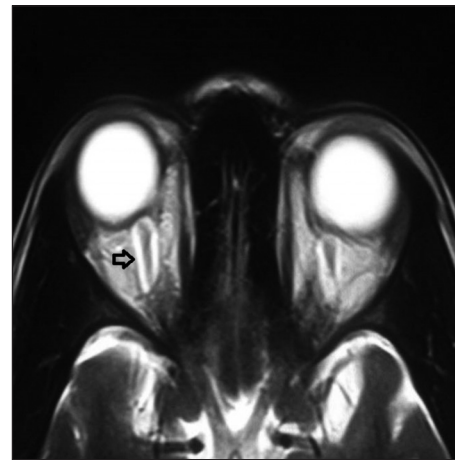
MRI showing optic nerves with increased perineural CSF spaces. MRI = Magnetic resonance imaging, CSF = Cerebrospinal fluid
